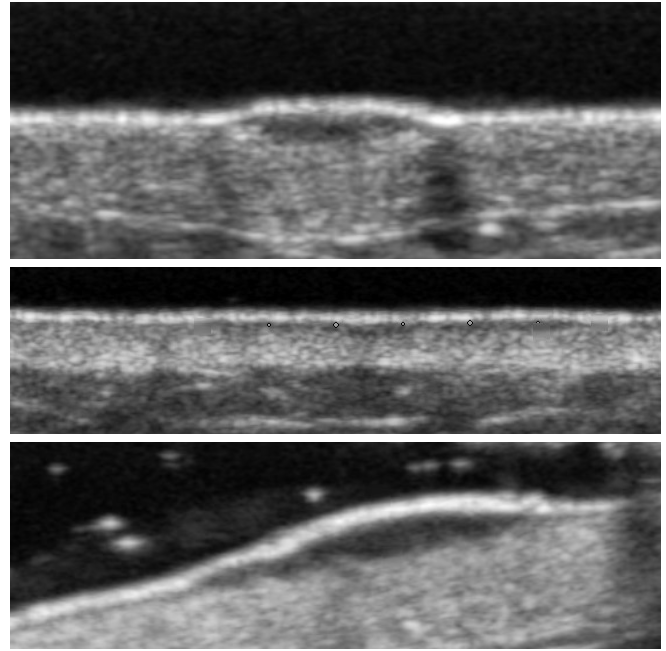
High-frequency ultrasound images of different types of skin lesions (from up to down: Benign Nevus, Basal Cell Carcinoma and Malignant Melanoma.) In some cases, certain differential features, such as shape, speckle pattern or echogenicity are noticeable even by naked eyes.
